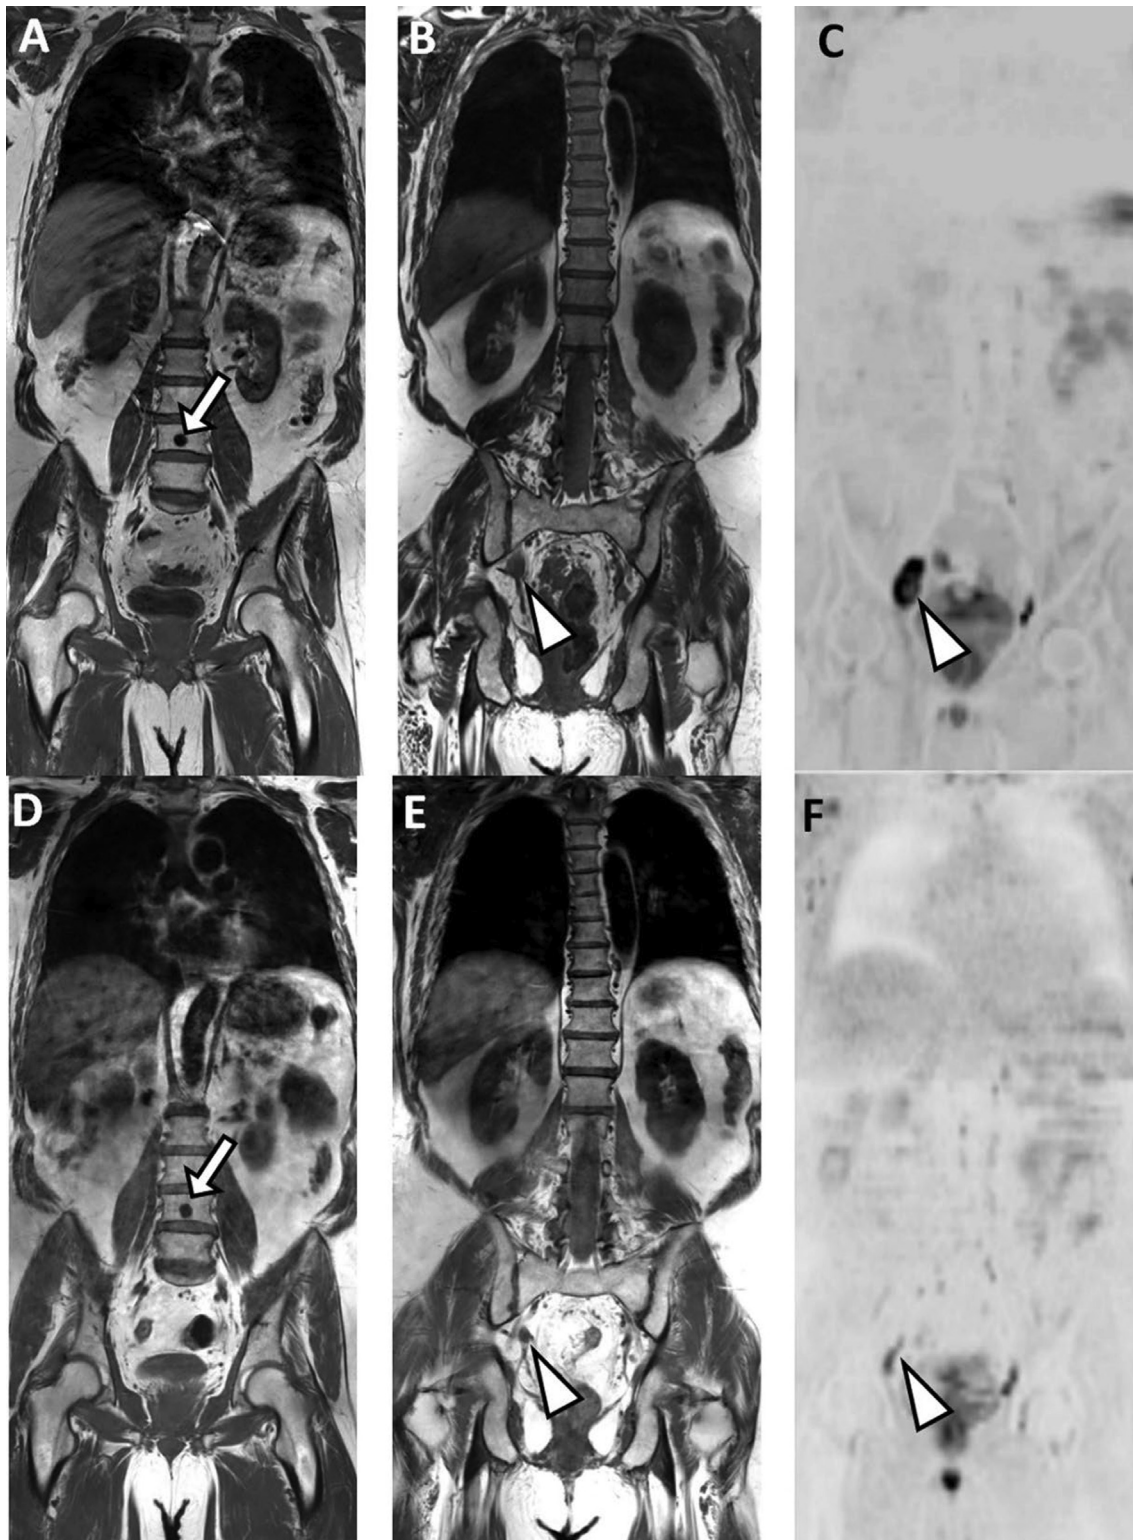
Response of nodal metastasis and stability of bone metastasis in a 75-yr-old man with metastatic castration-resistant prostate cancer (response assessment category 2). Comparison of whole-body magnetic resonance imaging before and after treatment. (A,B) Coronal T1-weighted images and (C) diffusion-weighted imaging ($b = 1000 \text{ s/mm}^2$, inverted gray scale) typical bone metastasis within the L3 vertebral body (arrow in A) and right iliac node metastases (arrowheads in B and C). (D–F) Corresponding 6-mo follow-up images show stability in the size of the L3 bone lesion (arrow in D) but almost complete disappearance of the metastatic nodes (arrowheads in E and F).
